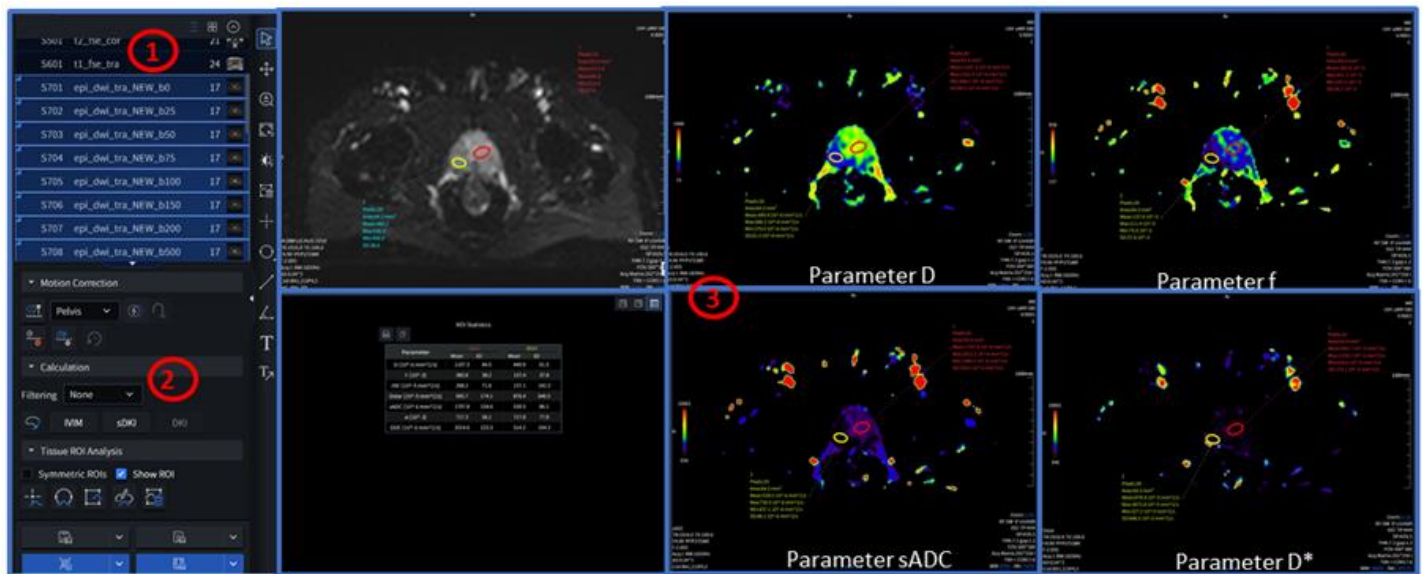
Representative IVIM MRI analysis in a 59-year-old male with a prostate lesion, demonstrating quantitative differences between healthy and malignant tissue regions. The images show manually placed ROIs in healthy peripheral zone (yellow) and lesion (red). Region 1 is study list where exam series can be selected. Region 2 is the control panel optional motion correction, filtering, model fitting, and calculation of parameters. Region 3 is where one can place ROIs, view pseudo-color maps, check statistics and export/push to PACS#.
